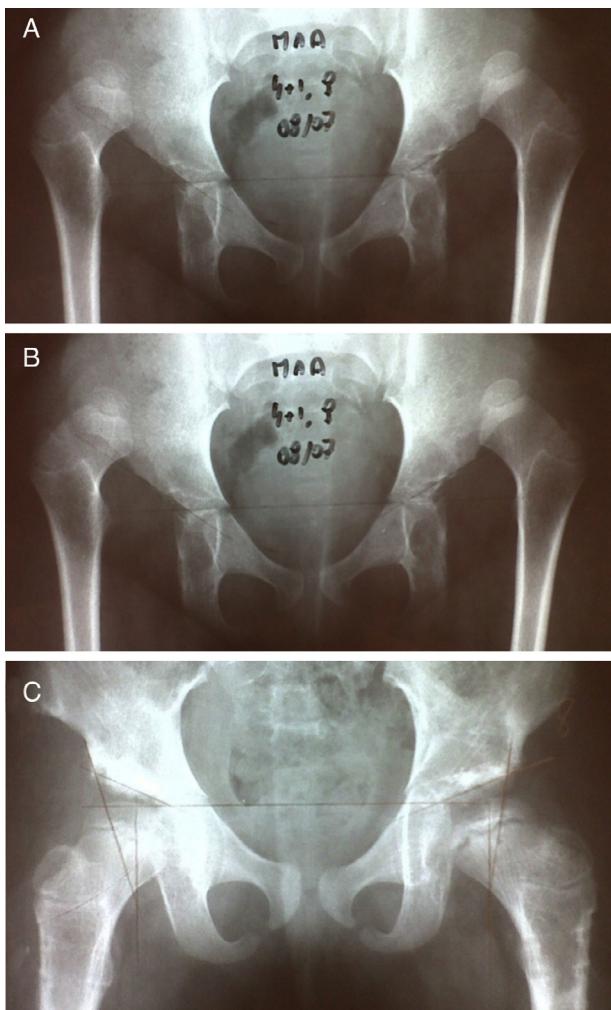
Female patient aged four years and one month: preoperative X-ray in August 2007 (A). X-ray on August 16, 2009, two years and five months after operation on right hip and one year and six months after operation on left hip (B). X-ray on October 2, 2010, three years and three months after operation on right hip and two years and eight months after operation on left hip, presenting type I necrosis of the femoral head (C).
